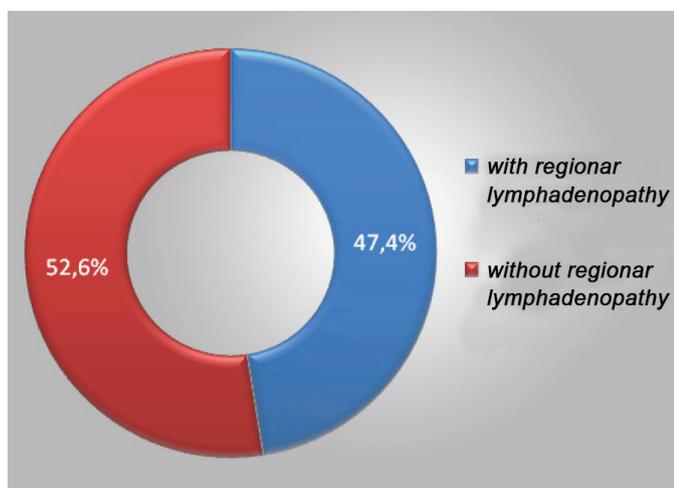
Involvement of regional lymph nodes during GC according to CT
